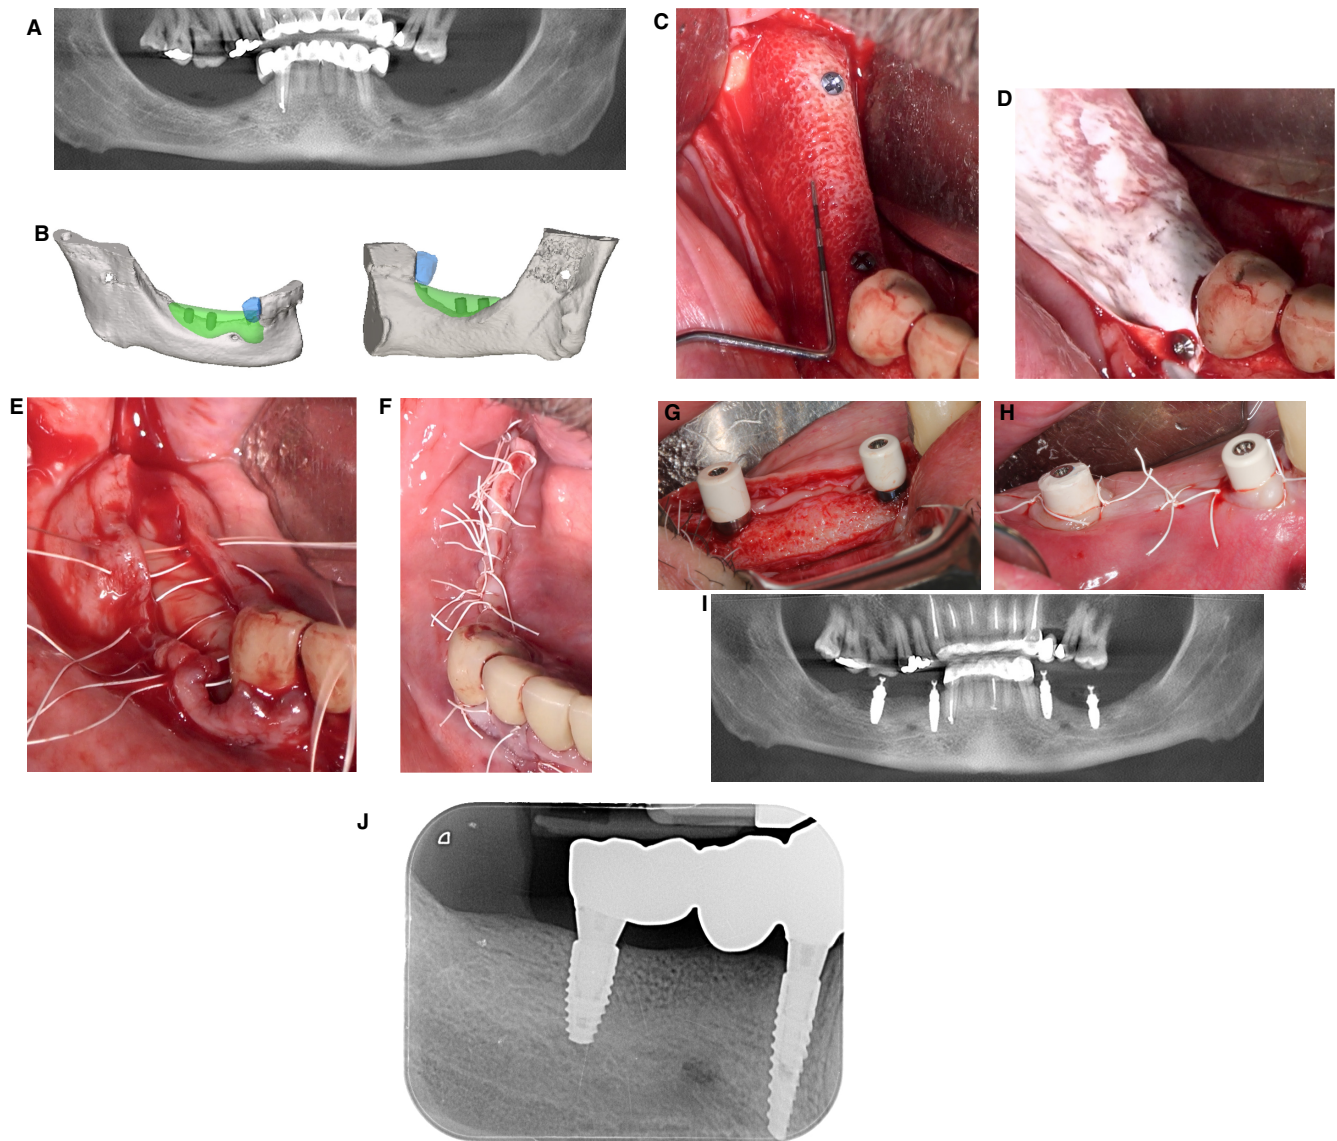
Representative case of the use of a computer-aided design/computer-aided manufacturing-customized allogenic bone graft. A, Patient presenting with bilateral vertical bone deficiencies in the posterior mandible. B, CAD of the allogenic bone blocks that will be placed in the affected areas. C and D, Intrasurgical view of the block placed after its fixation and covering with a native collagen membrane. E and F, Suturing of the surgical area with a combination of internal mattress sutures and single stitches. G–I, Implant placement in the ideal position 6 months later. J, Periapical radiograph of the implant-supported restoration 5 months after implant placement. Case kindly provided by Dr. Juan Blanco (University of Santiago de Compostela, Spain). computer-aided design/computer-aided manufacturing, computer-aided design/computer-aided manufacturing
